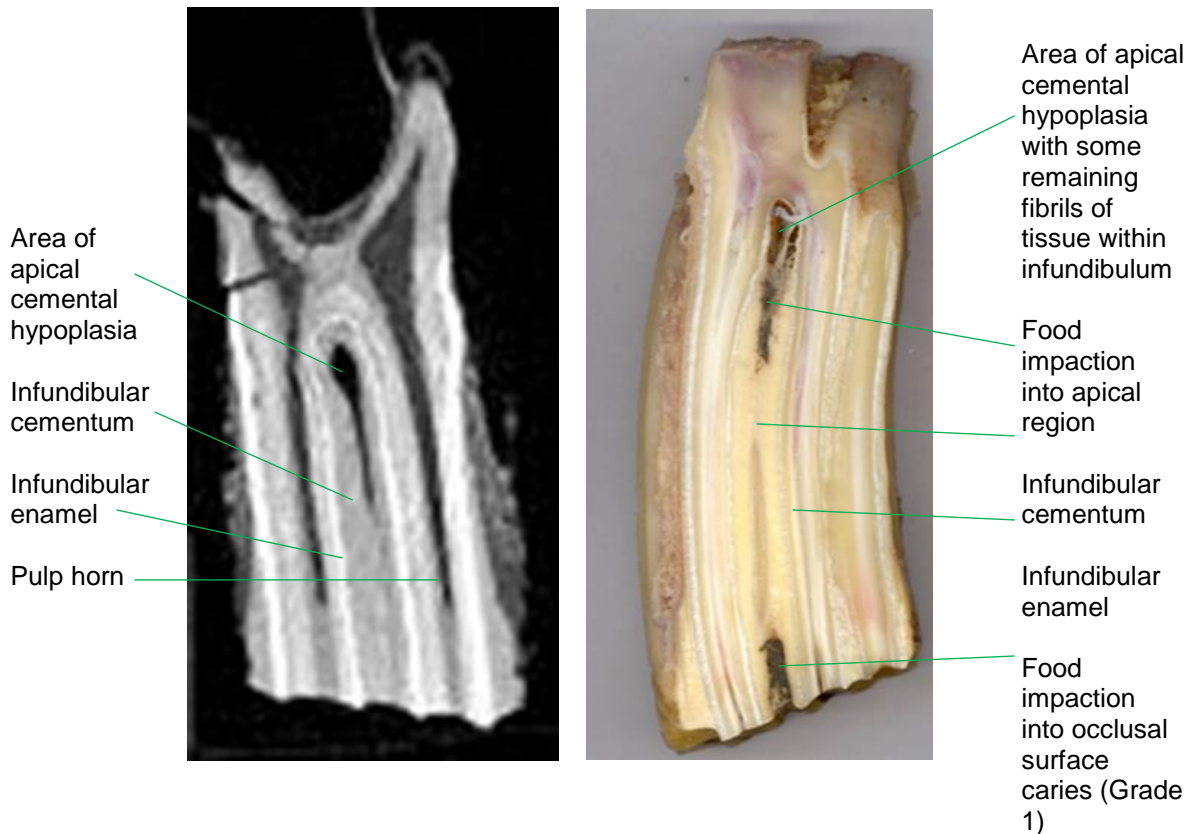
Computed tomographic scans (longitudinal sections) of maxillary cheek teeth and of similar gross anatomical longitudinal sections showing examples of different infundibular lesions.
